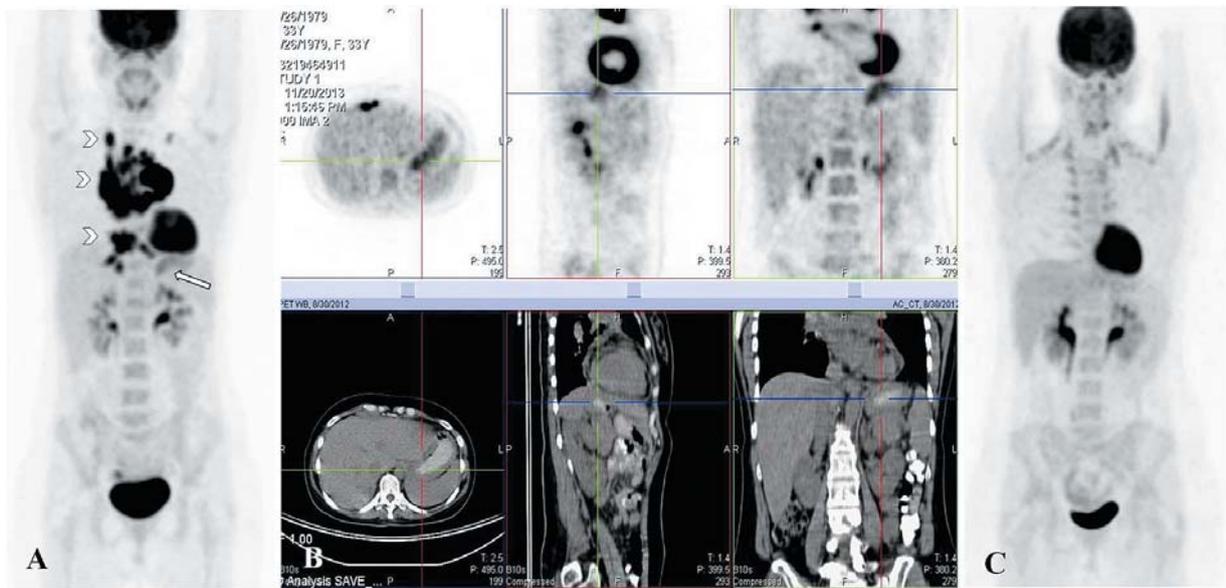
A: Pre-treatment positron emission tomography/ computed tomography (PET/CT) maximum intensity projection (MIP) indicating a large, strongly-hypermetabolic mediastinal mass (Maximum standardized uptake value, SUV_{max} 21.5) with other associated hypermetabolic mediastinal and supraclavicular nodal localizations (arrowheads). A lower intensity uptake is evident at the gastric wall (SUV_{max} 5.1) just below the left ventricle (arrow). B: Multiplanar depiction of the hypermetabolic gastric wall lesion at the level of the fundus (PET/CT MIP and CT reconstructions). C: Post-chemotherapy PET/CT MIP indicating complete resolution of all lymphomatous sites, including the gastric one. There is evidence of activated brown fat with thoracic paraspinal and supraclavicular foci of (18)F-fluorodeoxyglucose (^{18}F -FDG) uptake bilaterally, without clinical significance.
